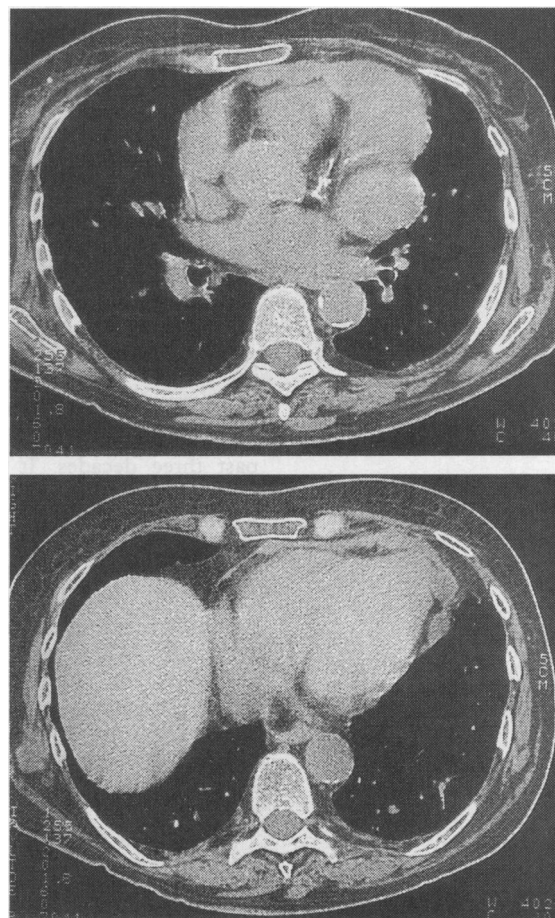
Computed tomograms taken with mediastinal window setting at level of left atrium (top) and ventricles (bottom). The pericardium is greatly thickened and lobulated predominantly along the anterior and left lateral cardiac borders
